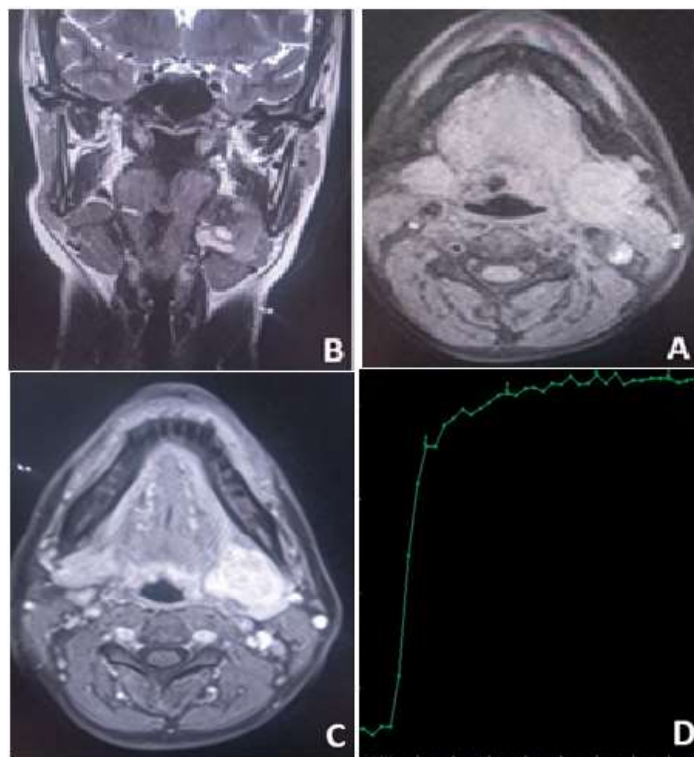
MRI of the submandibular region. A: Axial T1-weighted image without contrast; B: Coronal T2-weighted image; C: Axial T1-weighted image with contrast; D: Type C perfusion curve. A mass in the left submandibular gland measuring $3.7 \times 2.7 \times 2.8$ cm, with irregular contours, isointense on T1-weighted imaging, heterogeneous on T2-weighted imaging, with intense enhancement, ADC = 0.9, and a type C perfusion curve.
